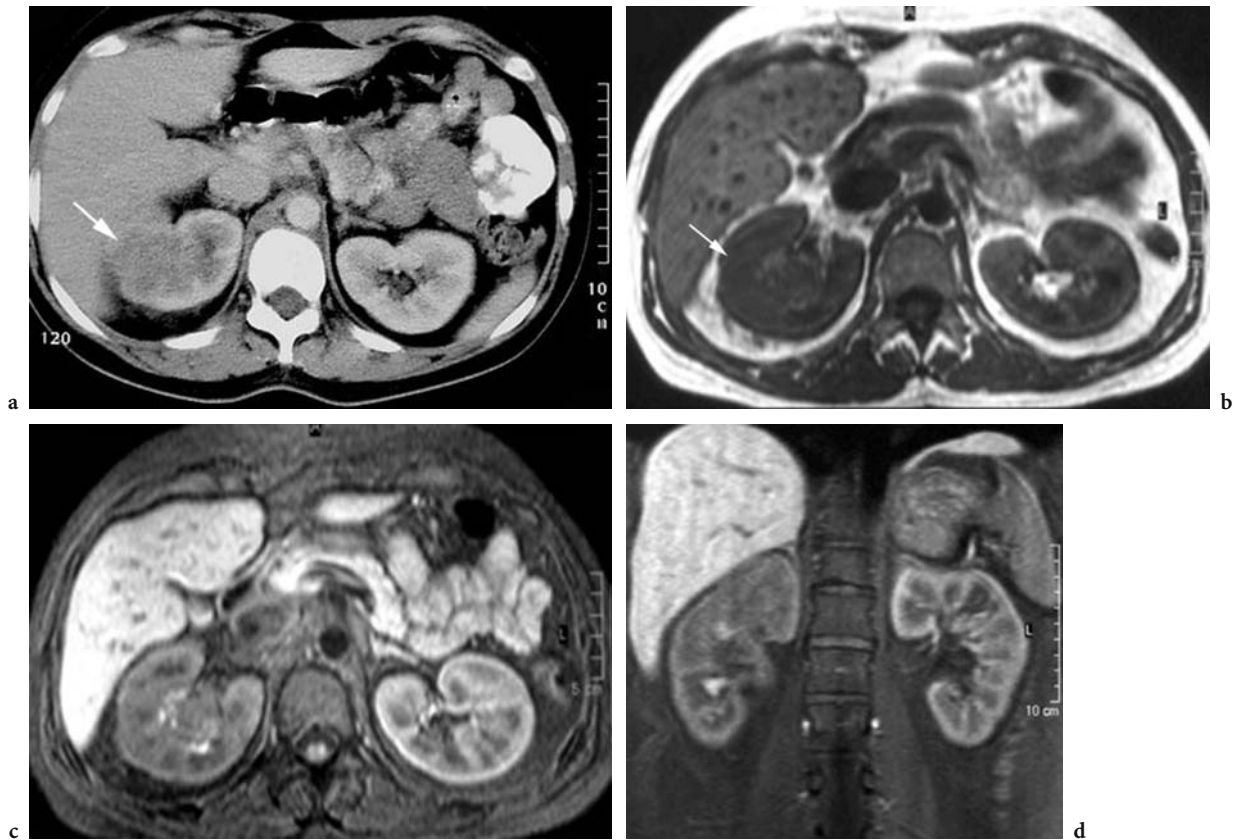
Infiltrative renal Hodgkin disease in a 32-year-old woman. a Axial contrast-enhanced CT scan shows hypodense infiltration (*arrow*) of the right kidney. The kidney is very slightly enlarged in comparison with the left kidney. b Axial unenhanced T1-weighted MR image shows the infiltration (*arrow*) to be slightly hypointense relative to the renal cortex. This infiltration obliterates the normally hyperintense renal sinus fat. c Axial and d coronal fat-suppressed contrast-enhanced T1-weighted MR images show minimal enhancement of the cortex of the right kidney due to diffuse infiltration. The reniform shape of the right kidney is maintained. (Image courtesy of L. Dobrovolskiene)
